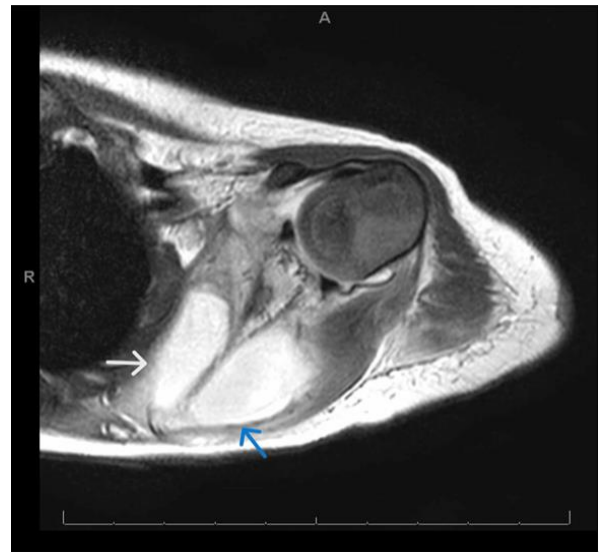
Left-shoulder MRI T2 Axial cut with contrast showed fluid loculations in the infraspinatus (blue arrow) and subscapularis (white arrow) muscles. The fluid loculations along the infraspinatus and the subscapularis appeared to be connected along the medial border of the scapula.
